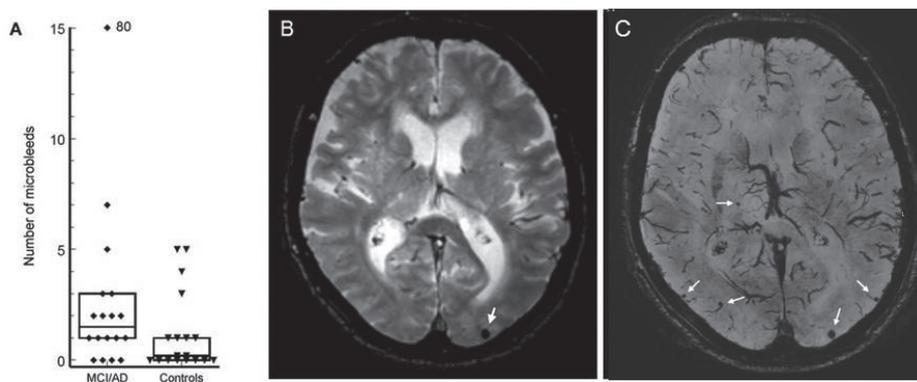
Total number of microbleeds at 7Tesla MRI in patients with MCI/AD and controls (box represents median with interquartile range) (A) and an example of a single slice T2*-weighted MR image at 3Tesla MRI (B) and 7Tesla MRI (second echo)
